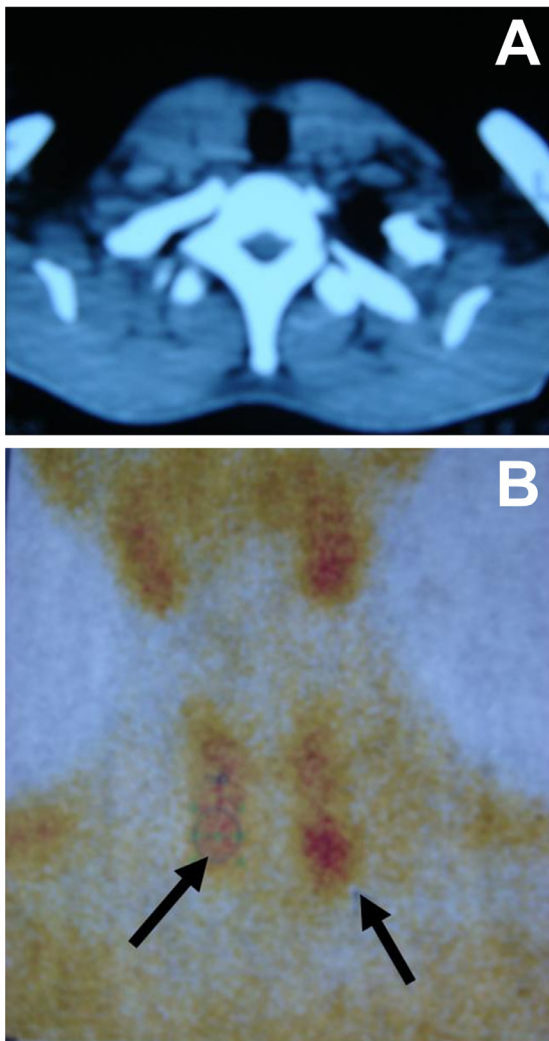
Images of the parathyroid tumors in the index case. (A), Computed tomography. (B) Emission computed tomography.
